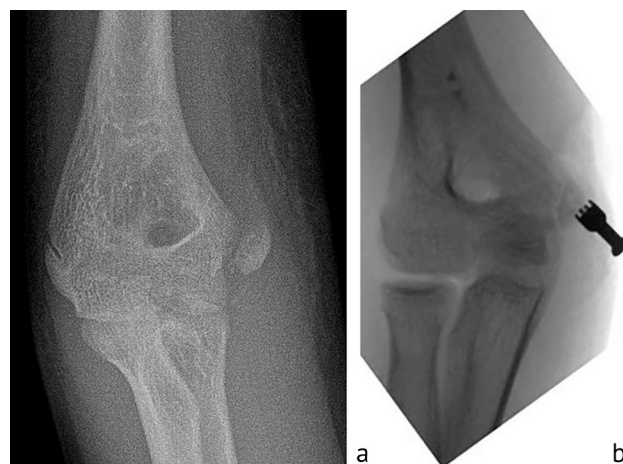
Medial epicondyle fracture: a – radiograph at admission; b – reduction and osteosynthesis
